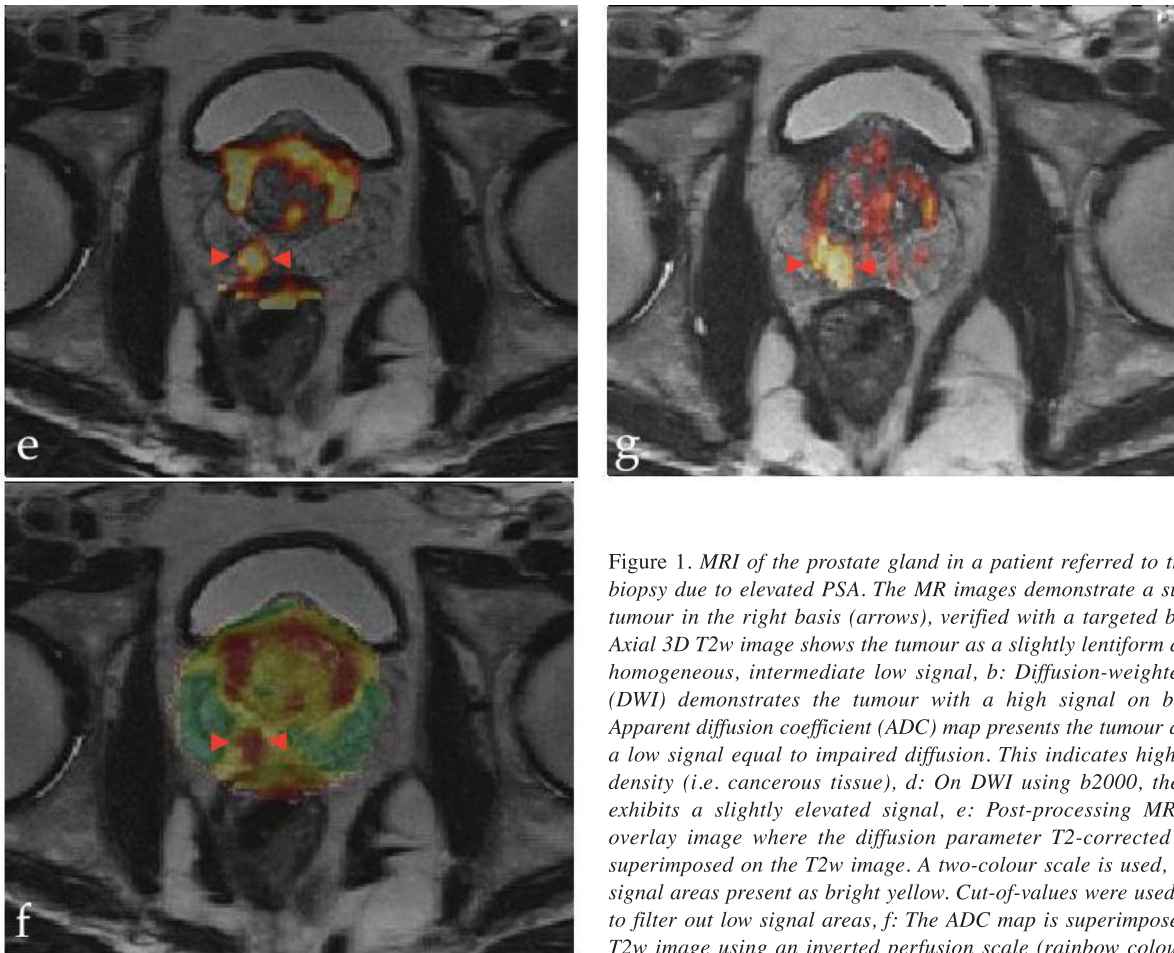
MRI of the prostate gland in a patient referred to the initial biopsy due to elevated PSA. The MR images demonstrate a suspicious tumour in the right basis (arrows), verified with a targeted biopsy. a: Axial 3D T2w image shows the tumour as a slightly lentiform area with homogeneous, intermediate low signal, b: Diffusion-weighted image (DWI) demonstrates the tumour with a high signal on b1000, c: Apparent diffusion coefficient (ADC) map presents the tumour as having a low signal equal to impaired diffusion. This indicates high cellular density (i.e. cancerous tissue), d: On DWI using b2000, the tumour exhibits a slightly elevated signal, e: Post-processing MRI colour overlay image where the diffusion parameter T2-corrected bmax is superimposed on the T2w image. A two-colour scale is used, and high signal areas present as bright yellow. Cut-off values were used in order to filter out low signal areas, f: The ADC map is superimposed on the T2w image using an inverted perfusion scale (rainbow colour scale). Cut-off values were adjusted in order for the red-pink-white colours represent low ADC values ( $<100 \text{ mm}^2/\text{s}$ ), while green/blue reveals high ADC values ( $>170 \text{ mm}^2/\text{s}$ ). g: This image demonstrates the superimposed b2000 image. A two-colour scale is used as described in (e). It displays the improvement of the spatial resolution, and the ability to detect tumours well when compared to the native b2000.
